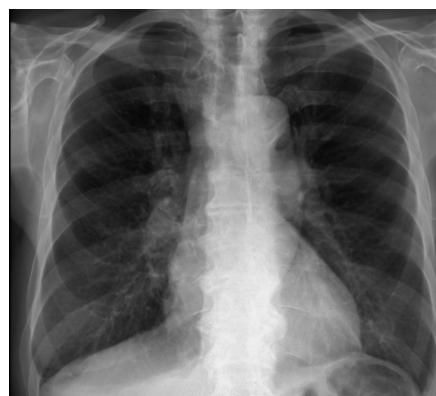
Chest x-ray after 7-days of methyl-prednisolone shows improvement.
